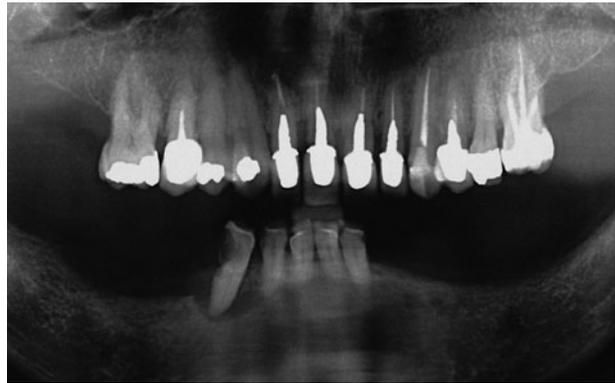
Pre-operative panoramic radiograph: failure of incisors, due to major bone loss, incongruous intra-canal posts and a cystic lesion on tooth 12, are appreciable. Intra-bony defects appeared more severe in correspondence to tooth 26, whereas a more horizontal pattern of periodontal support loss can be detected on the remaining elements.
